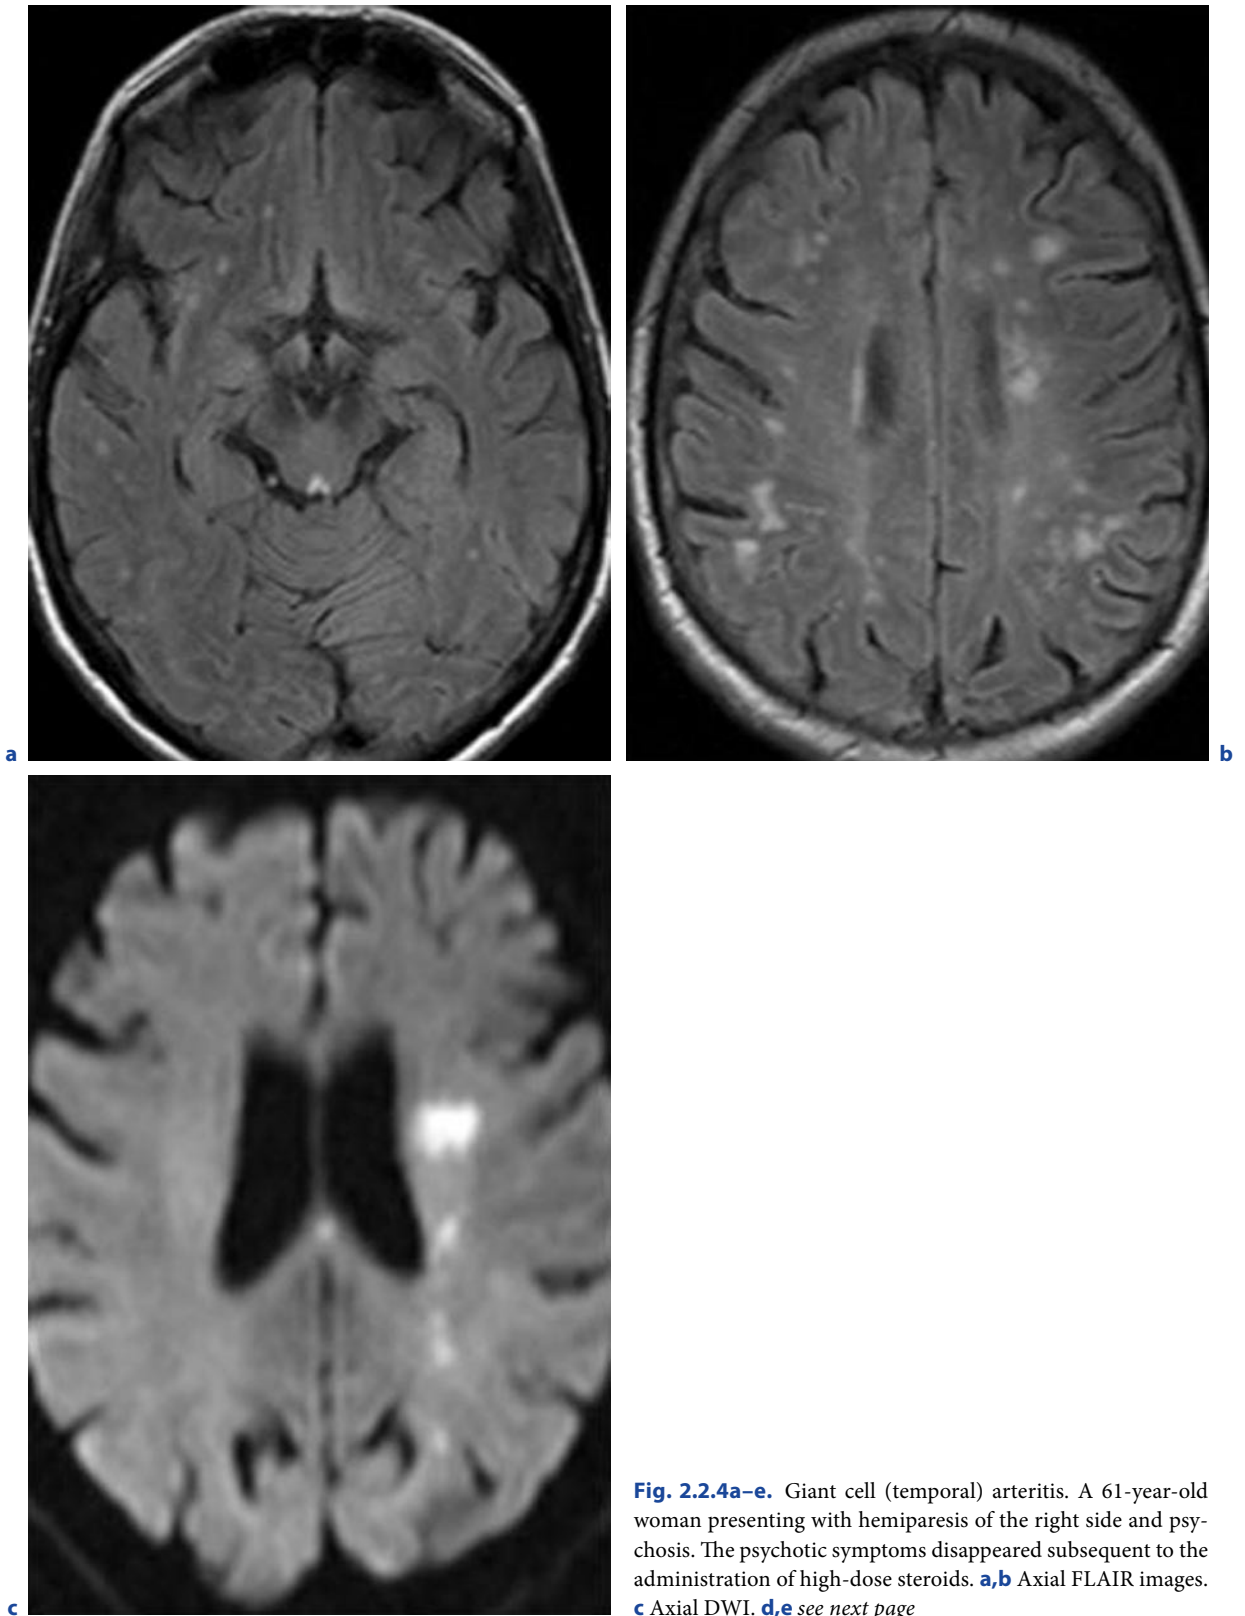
Giant cell (temporal) arteritis. A 61-year-old woman presenting with hemiparesis of the right side and psychosis. The psychotic symptoms disappeared subsequent to the administration of high-dose steroids. a,b Axial FLAIR images. c Axial DWI. d,e see next page
